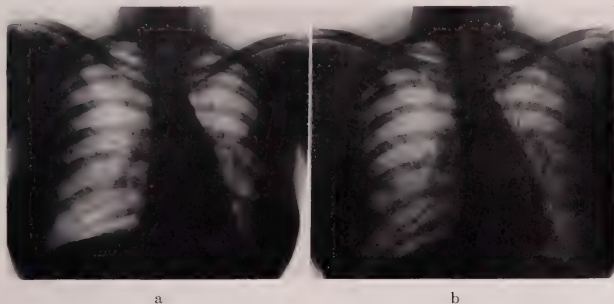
Roentgenogram made October 11, 1946 and April 21, 1947 showing marked resolution of the atelectatic pneumonic process in the lower half of the left lower lobe.
